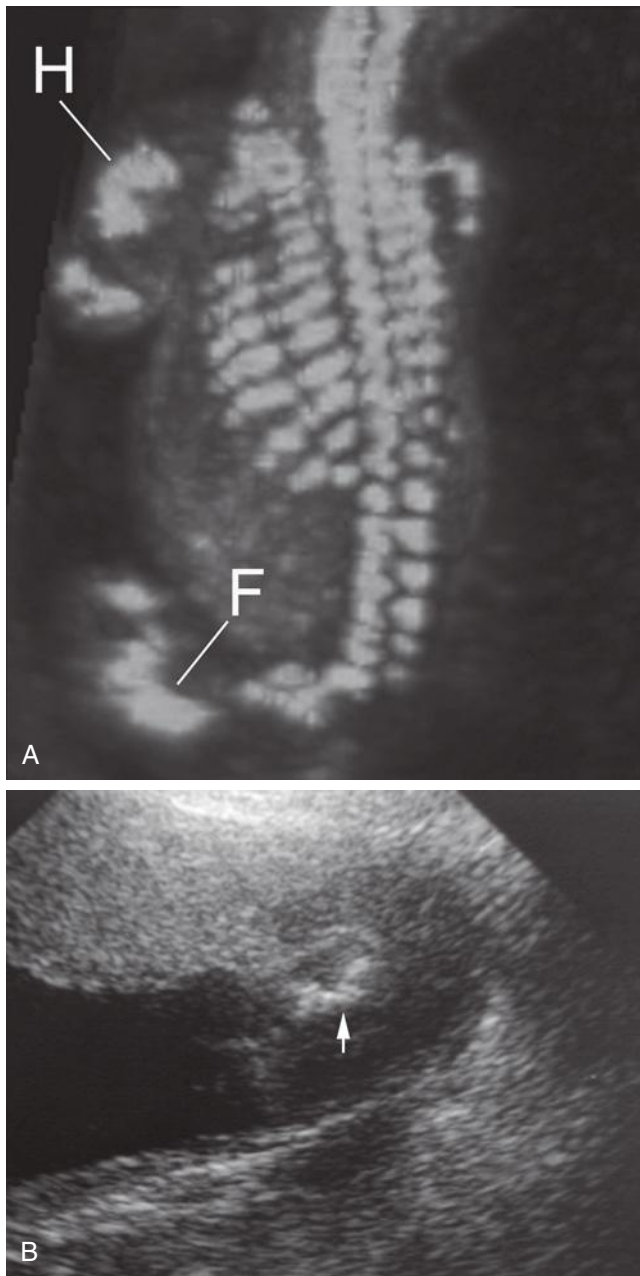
A, Three-dimensional sonogram in a fetus with osteogenesis imperfecta type II. The volume dataset was rendered using the maximum intensity mode. Multiple fractures in the ribs are present. Note the severe bowing and shortening of the femur (F) and humerus (H). B, Sonogram of a fetus with osteogenesis imperfecta type II. The femur is markedly shortened (*arrow*) with multiple fractures.
